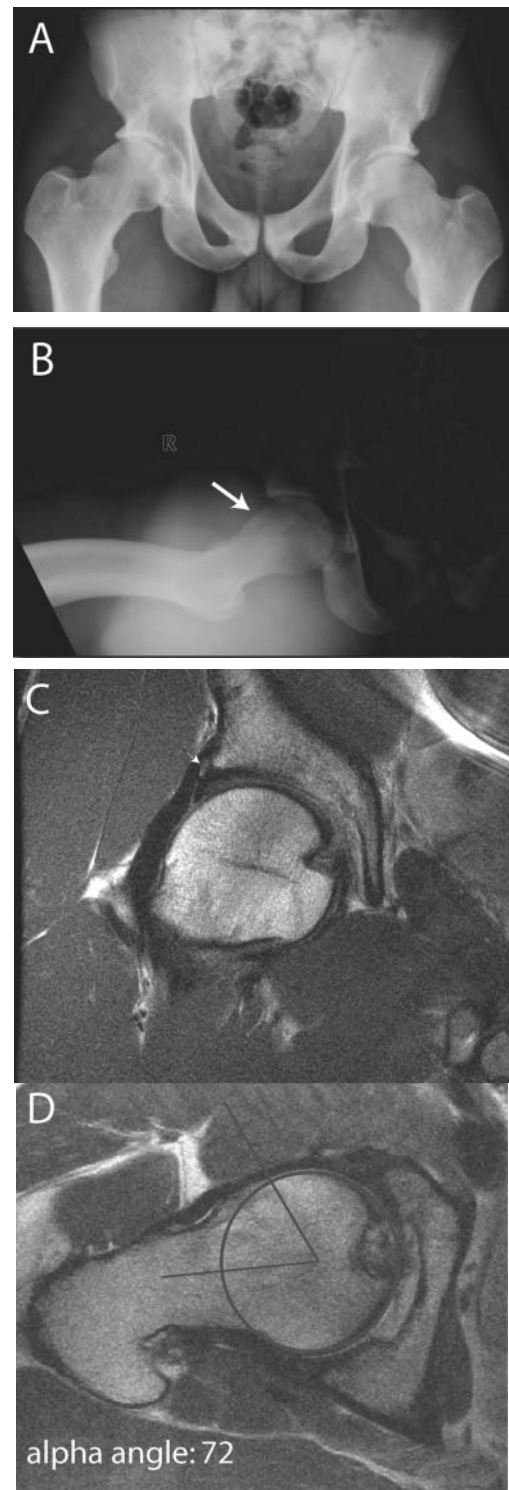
Radiographic evaluation of an athlete with hip pain. A, anteroposterior pelvis of a National Football League athlete with a pincer lesion. B, elongated neck/Dunn view of a hip demonstrating a cam lesion (arrow) indicative of femoroacetabular impingement. C, coronal MRI demonstrating a tear of the anterior labrum that extends to the base of the superior labrum (arrowhead). D, axial MRI demonstrating a cam-type lesion and an increased alpha angle as described by Nötzli et al.²⁸
